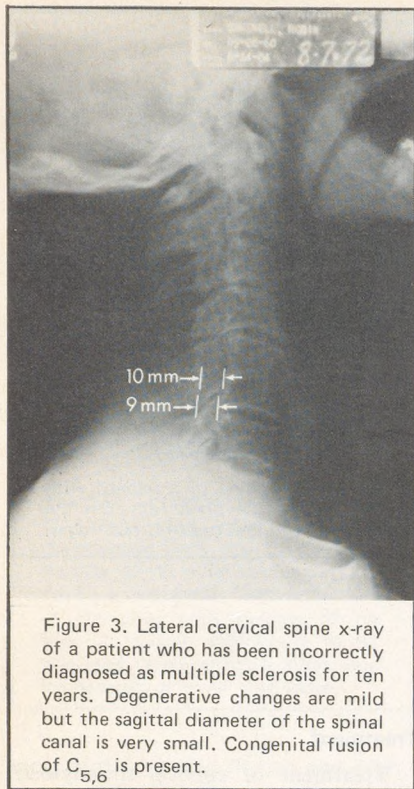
Lateral cervical spine x-ray of a patient who has been incorrectly diagnosed as multiple sclerosis for ten years. Degenerative changes are mild but the sagittal diameter of the spinal canal is very small. Congenital fusion of C<sub>5,6</sub> is present.
